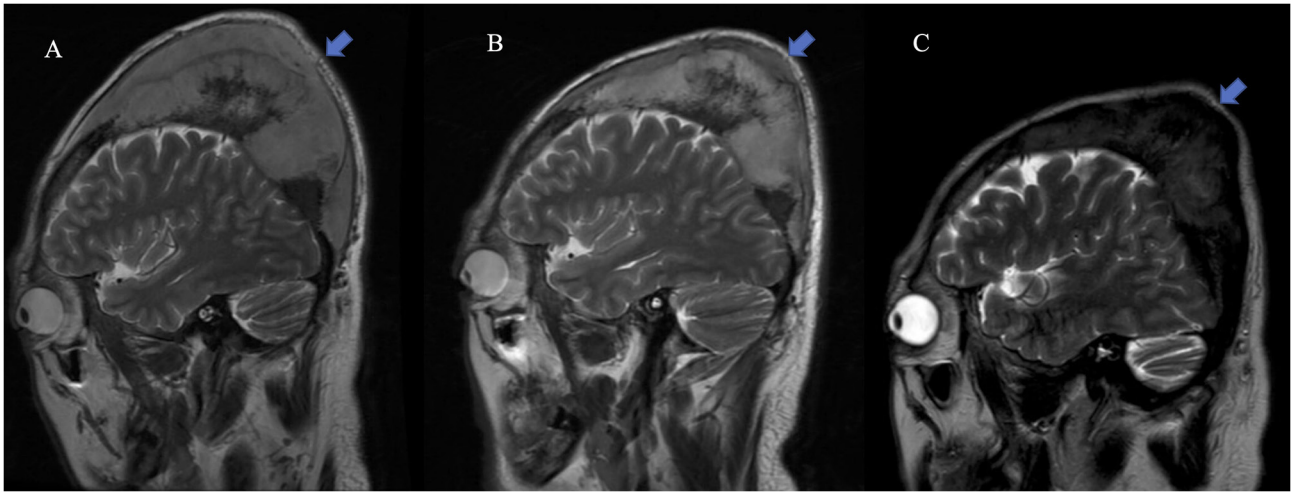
Serial MRI monitoring of the right parietal extramedullary lesion after fully humanized B-cell maturation antigen chimeric antigen receptor T-cell infusion. Closely matched sagittal cutting planes are shown across time points. (A) Baseline, (B) day 13 after infusion and (C) 9 months after infusion, demonstrating progressive reduction of the extraosseous soft-tissue component.
